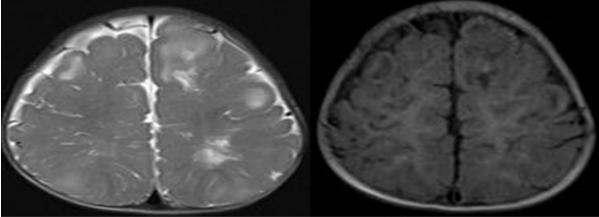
MRI Brain (plain axial) – T2WI (A) and T1WI (B)
